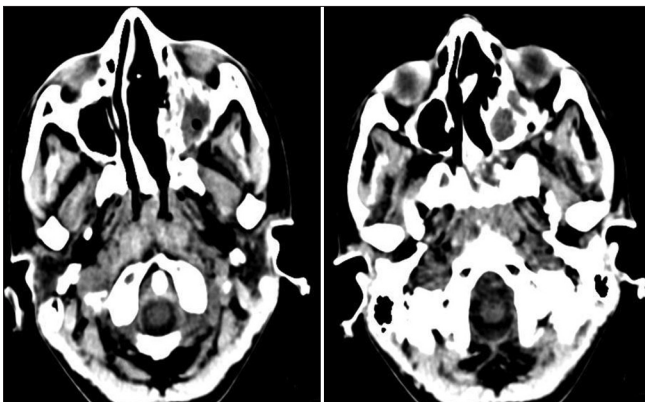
Computed tomography images post chemotherapy showing complete response
